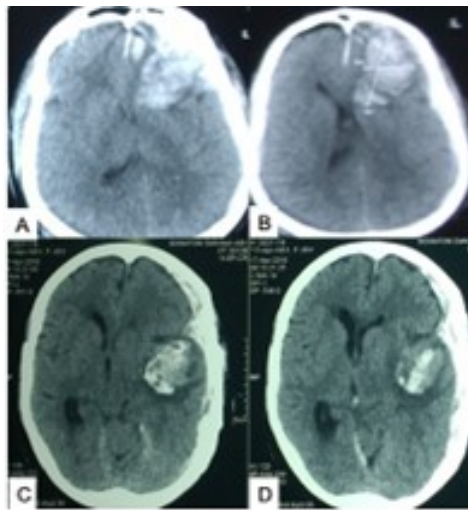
CT scans showing (A,B) burst frontal lobe; (C,D) the burst temporal lobe on left side. Source: Figure by authors.
